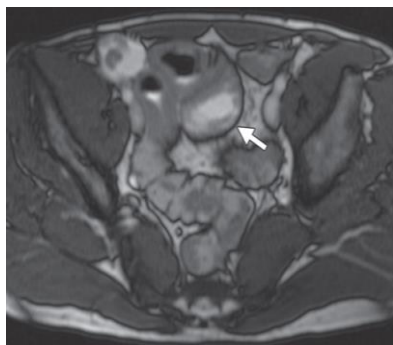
A 31-year-old man with abdominal pain, postprandial vomiting, weight loss, and a history of celiac disease. Axial T1-weighted fat-suppressed MR image with intravenous contrast material shows moderate homogeneous enhancement of the thickened bowel wall (arrow).
